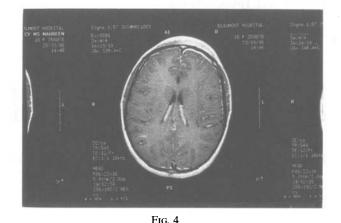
CT scan of *Case 2* fails to demonstrate intracranial extension of disease process.
